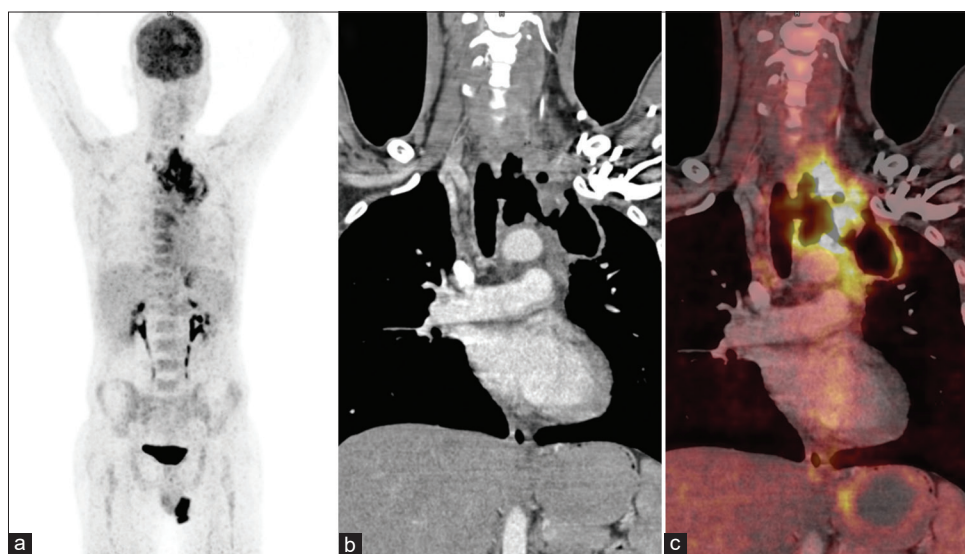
Maximum intensity projection image of positron emission tomography/computed tomography (a) increased uptake in the mediastinum and the left thoracic region. Coronal computed tomography of the thoracic region (b) shows a fistulous communication between the trachea and lung parenchyma (tracheoparenchymal fistula). Fused coronal positron emission tomography/computed tomography (c) reveals fistulous communication between the trachea and lung parenchyma (tracheoparenchymal fistula)
